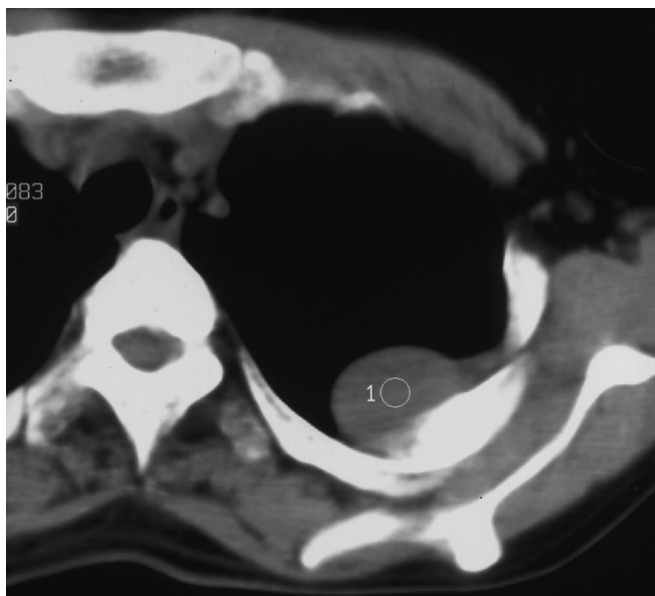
Chest computed tomography demonstrating homogenous soft-tissue-attenuating mass with sharp margin.
